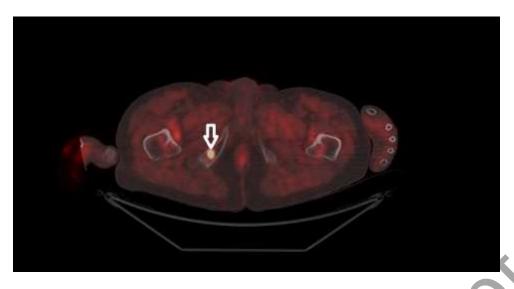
Increased FCH uptake in the right ischial bone (SUVmax 9.8) — suspicious for metastatic involvement.
